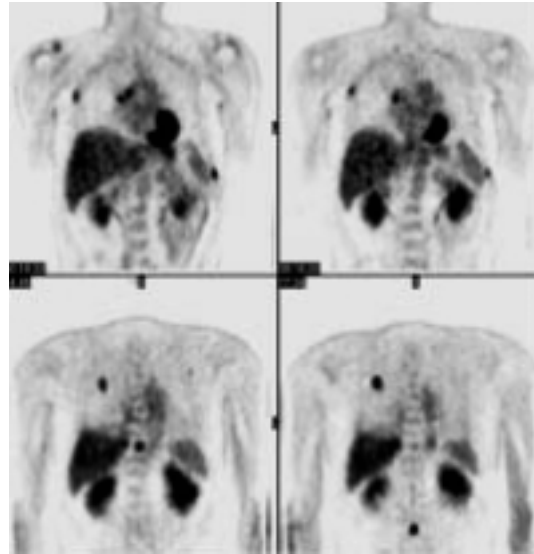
FFDG-PET 55-year-old man SPN RUL.
